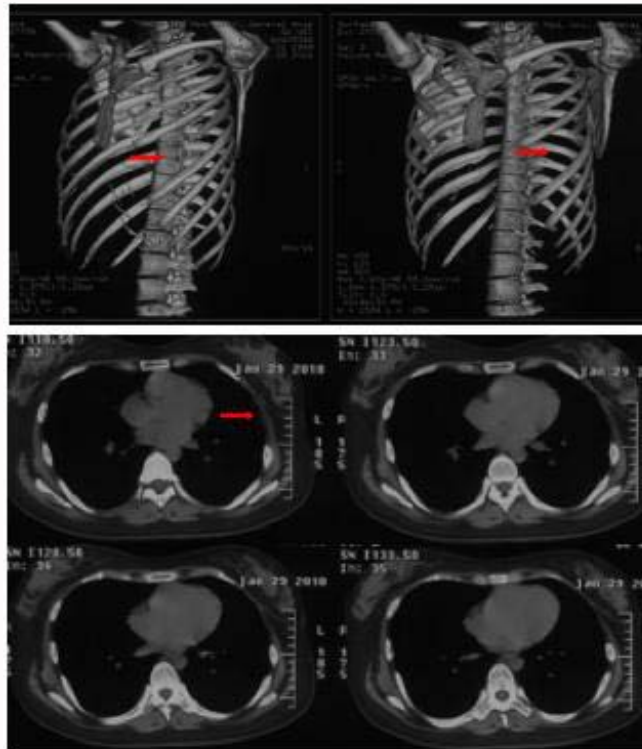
Computed tomography scans of chest after operation for 18-month. Upper panel showed a partial missing in the front of the left fifth rib (red arrows); lower panels also showed the missing of the left fifth rib (red arrow).
